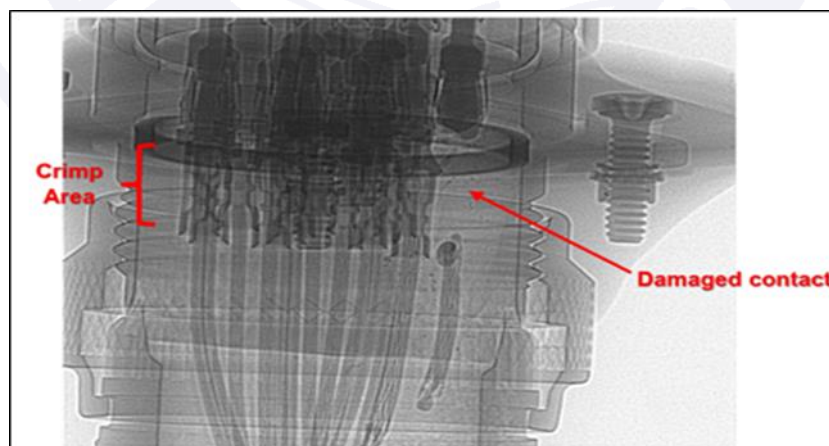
Overview of damage to the connector on an x-ray inspection.
